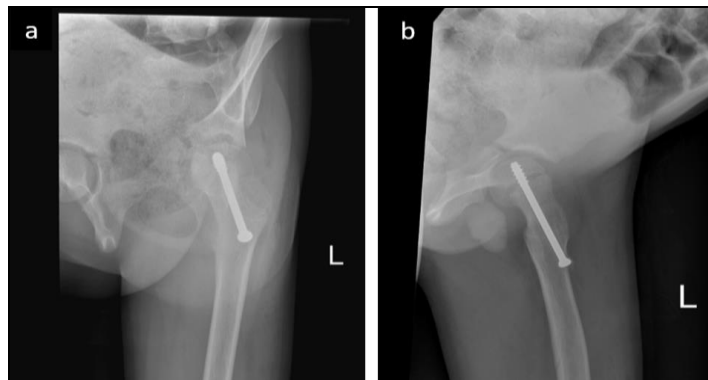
Radiographs of left hip anteroposterior (a) and lateral (b) views immediate post-surgery with in-situ fixation by partially threaded cancellous screw.
